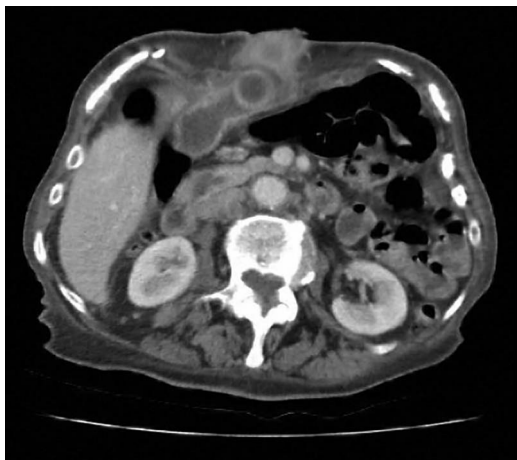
CT appearance of calculi in fistula (axial view).
